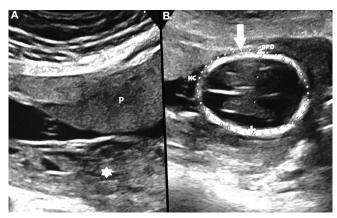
B-mode ultrasonography of uterus showing (A) normal placenta (P) (B) of live foetus (arrow) corresponding to 16 wk zero day anteriorly and posteriorly heterogeneous isoechoic mass with cystic spaces (star) suggesting molar pregnancy. HC, head circumference; BPD, biparietal diameter.
